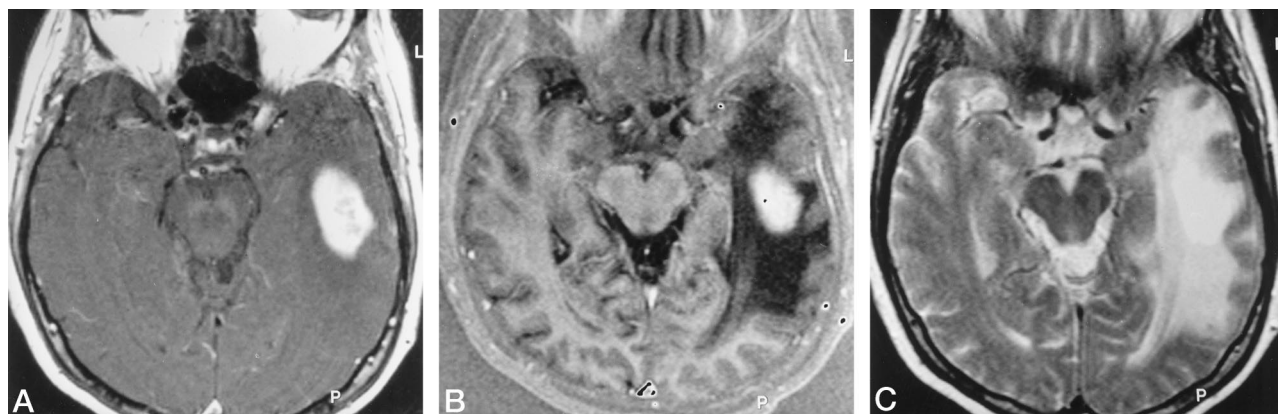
Although an area of solid tumor enhancement in the left temporal lobe is similarly apparent on the T1-weighted spin-echo image with on-resonance MTC (A) and the IR-EPI image (B), the surrounding vasogenic edema is much more apparent on the IR-EPI image. Depiction of vasogenic edema with the IR-EPI sequence approaches that of the T2-weighted turbo spin-echo image (C).
